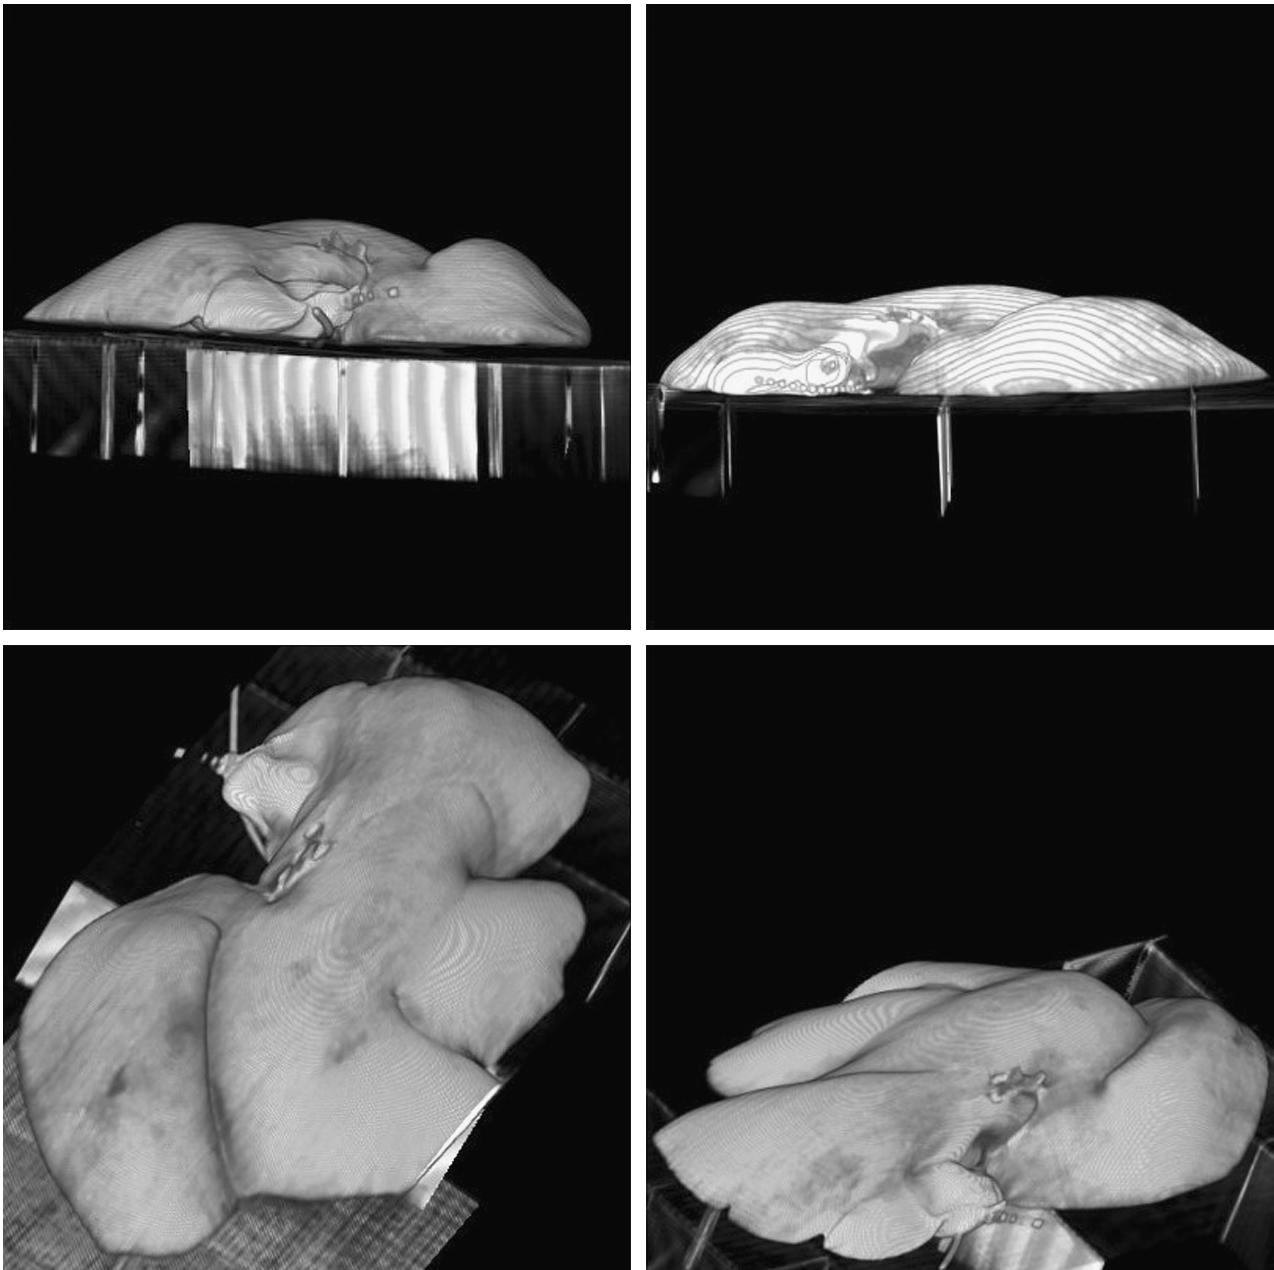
Four views of the liver's CT volume reconstructed from the single CT slices.
